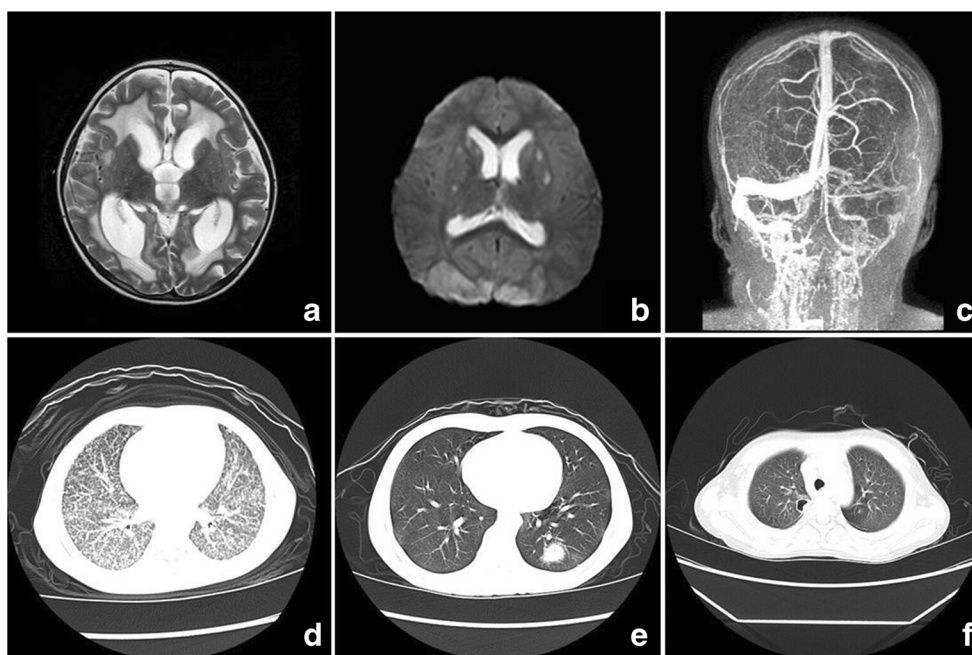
Imaging findings of pediatric cryptococcosis cases. a A 3-year-old boy who presented with fever and headache for one month. MRI axial T2-weighted image: presented clustered tiny foci that were hyperintense in T2-weighted images, dilated Virchow-Robin spaces (VRS) in the basal ganglia region, and hydrocephalus with encephaledema. b A 5-year-old boy who presented with fever and headache for 15 days. Cranial MRI axial DWI-weighted image: multiple patchy hyperintensities of gelatinous pseudocyst with multiple patchy hyperintensities on T1-, T2-, and DWI-weighted images in the basal ganglia region. c A 6-year-old girl who was admitted with headache and seizures for 20 days. Magnetic
